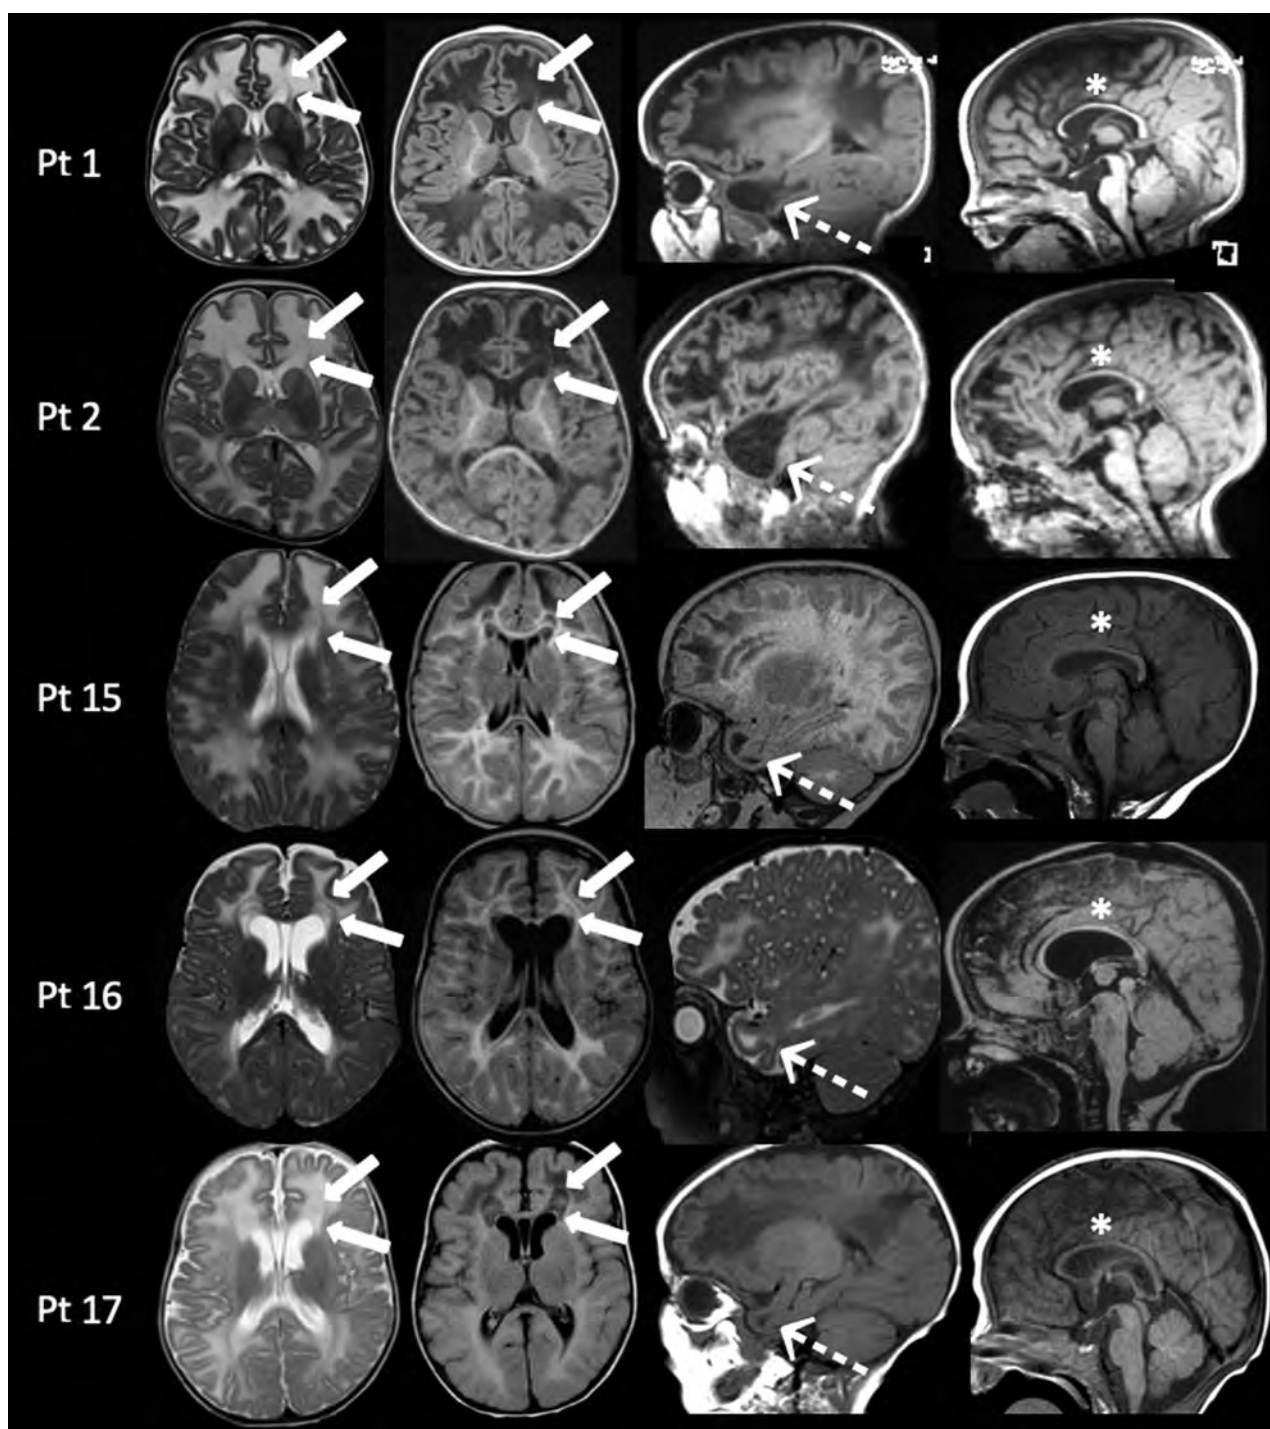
MR imaging findings in patients with galactosemia with subacute clinical presentations between 7 and 18 months of age. In all patients, axial images (*left columns*) show diffuse white matter edema associated with the presence of the double cap sign adjacent to the frontal horns of the lateral ventricles (*arrows*). On sagittal images (*right columns*), MR imaging demonstrates, in all patients, the presence of cystlike lesions of the temporal poles (*dotted arrows*) and thinning of the corpus callosum (*asterisks*). Pt indicates patient.
